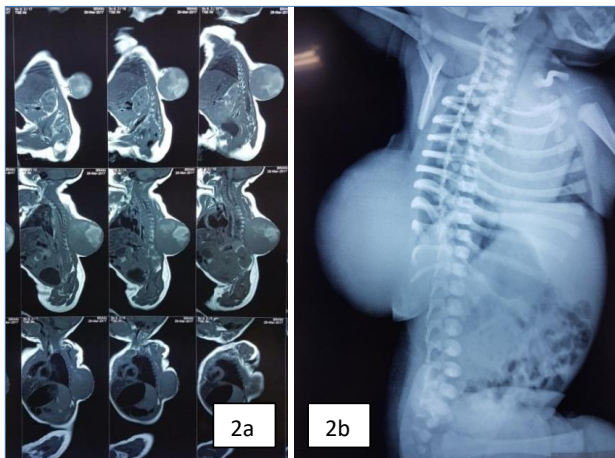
a) Post-natal MRI of thorax, showing paraspinal CIFS without any spinal cord infiltration b) Lateral plain x-ray of patient.
